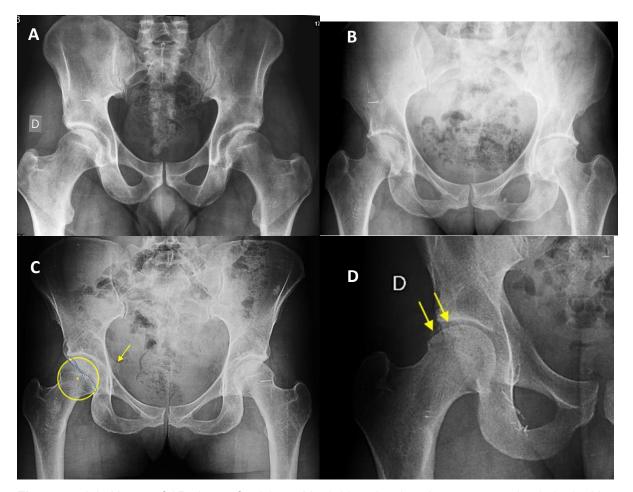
plain X-rays of AP views of pelvis and both hips showing; A. cross-over sign in both sides, B. bilateral coxa profunda, C. posterior wall sign and ischial spine sign, and D. os acetabuli in the right hip.
